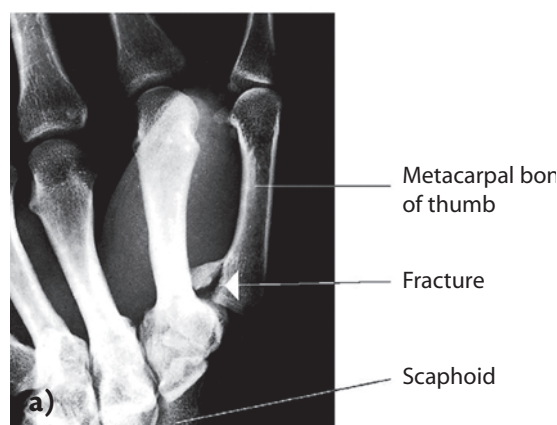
Fracture of the thumb's metacarpal (Bennett's fracture) spreads into the joint (intra-articular). a) X-ray of fracture of the thumb's metacarpal; b) boxing entails a risk of injury to the metacarpals. (With permission, by Bildbyrå, Sweden.)
